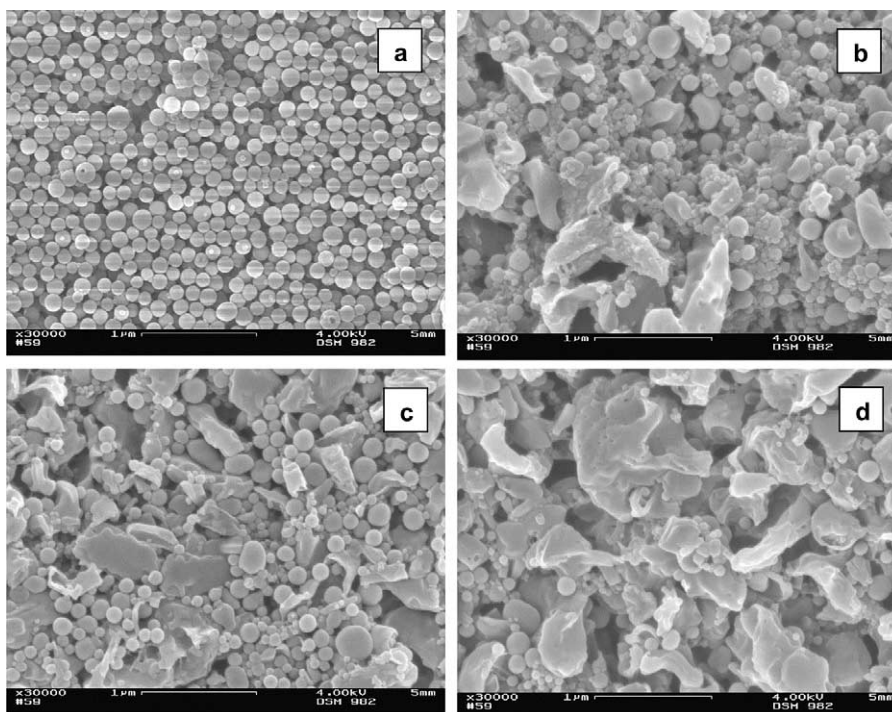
SEM images of PHBV particles prepared at different ultrasound power, (a) 80 W; (b) 160 W; (c) 240 W; (d) 320 W ($c_{\text{PEO/PS1:4}} = 7.5 \text{ wt\%}$, $c_{\text{PHBV}} = 10 \text{ g/l}$).
